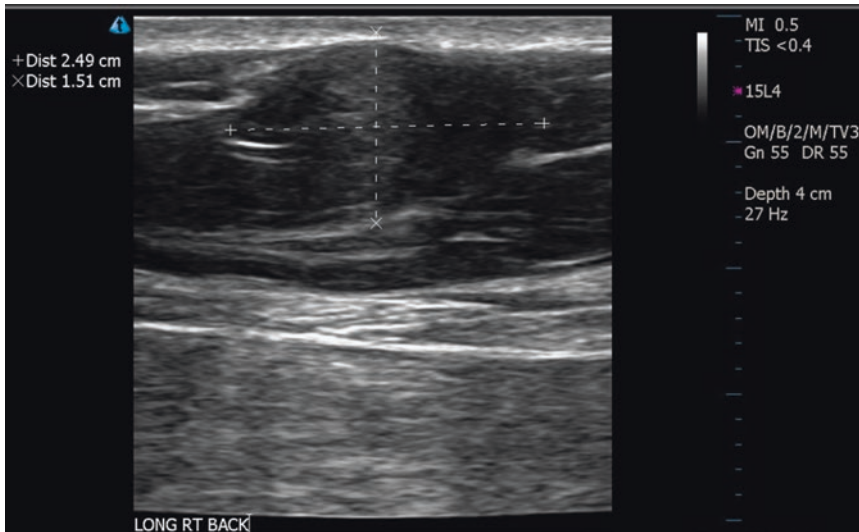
Ultrasound imaging shows a fatty consistency of the mass and defines its borders. There is no deep fascial extension
